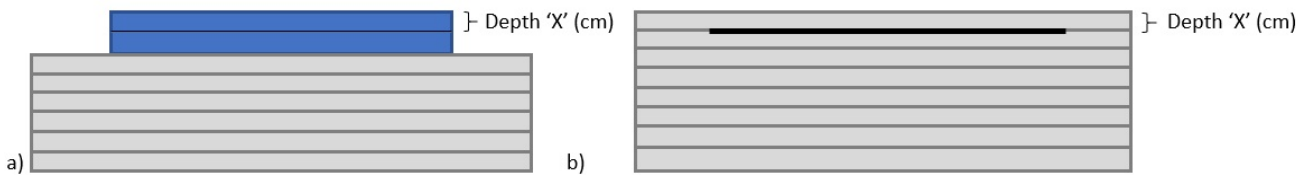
Reference EBT3 measurement: a) the cuboid was irradiated onto RW3 plates. The black line represents an MRI slice taken at a specific depth. b) the film is placed in between RW3 plates at the same depth as the acquired slice in the cuboid. Here the thicker black line represents the film.
